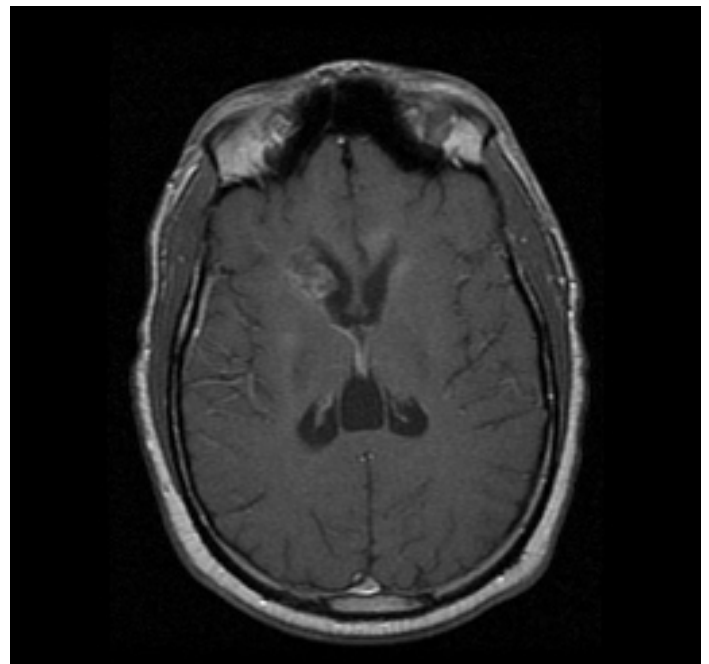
Brain MRI (T1 axial image post gadolinium) showing heterogeneous enhancement involving the right caudate nucleus and the genu of the corpus callosum with extension to periventricular white matter. Also, a linear enhancement is seen along ependymal lining of the right lateral ventricle.
